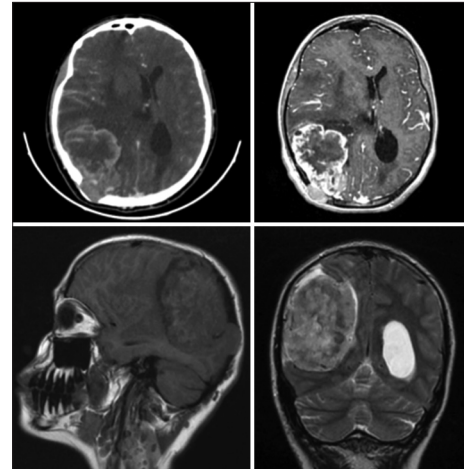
Preoperative brain computed tomography scan and brain magnetic resonance imaging show a large, heterogeneous contrast-enhancing mass located in the right parieto-occipital region. This mass extended extra-axially, reaching up to the occipital horn medially and involving the cortical bone of the inner table laterally.
